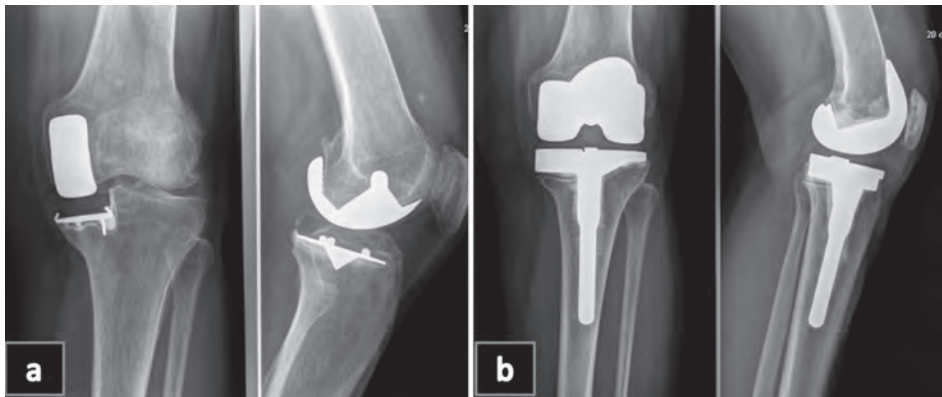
Shows a clinical case of a 57 year old lady, who presented to our service two years with ongoing medial knee pain following a UKA to UKA procedure, which had been performed for persistent pain which corresponded to a site of lysis and bony sclerosis under the medial tibial plateau. Both the pain and the radiographic lysis persisted after her UKA to UKA procedure (fig. 4a), and for which she had a UKA to TKA. Although resection was as conservative as possible through the sclerotic medial tibial bone, and medial augments used with a stemmed prosthesis, and clinical symptoms have improved, the area of lysis persists at one year following her revision to TKR (fig. 4b).
